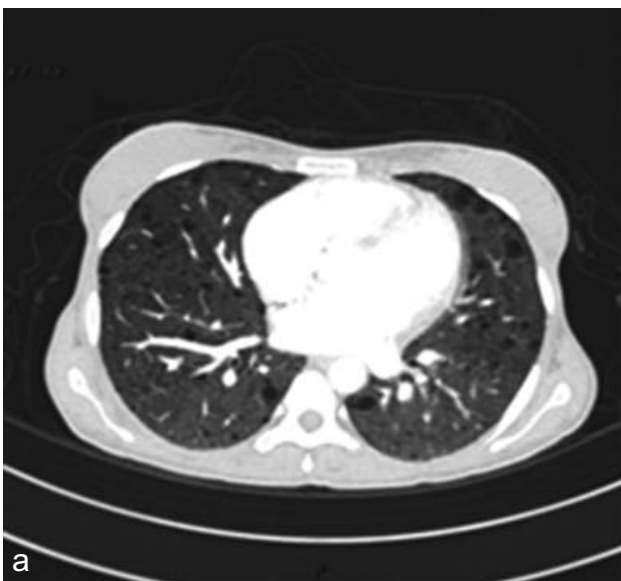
Axial slices of CT chest on lung window showing multiple LAM
